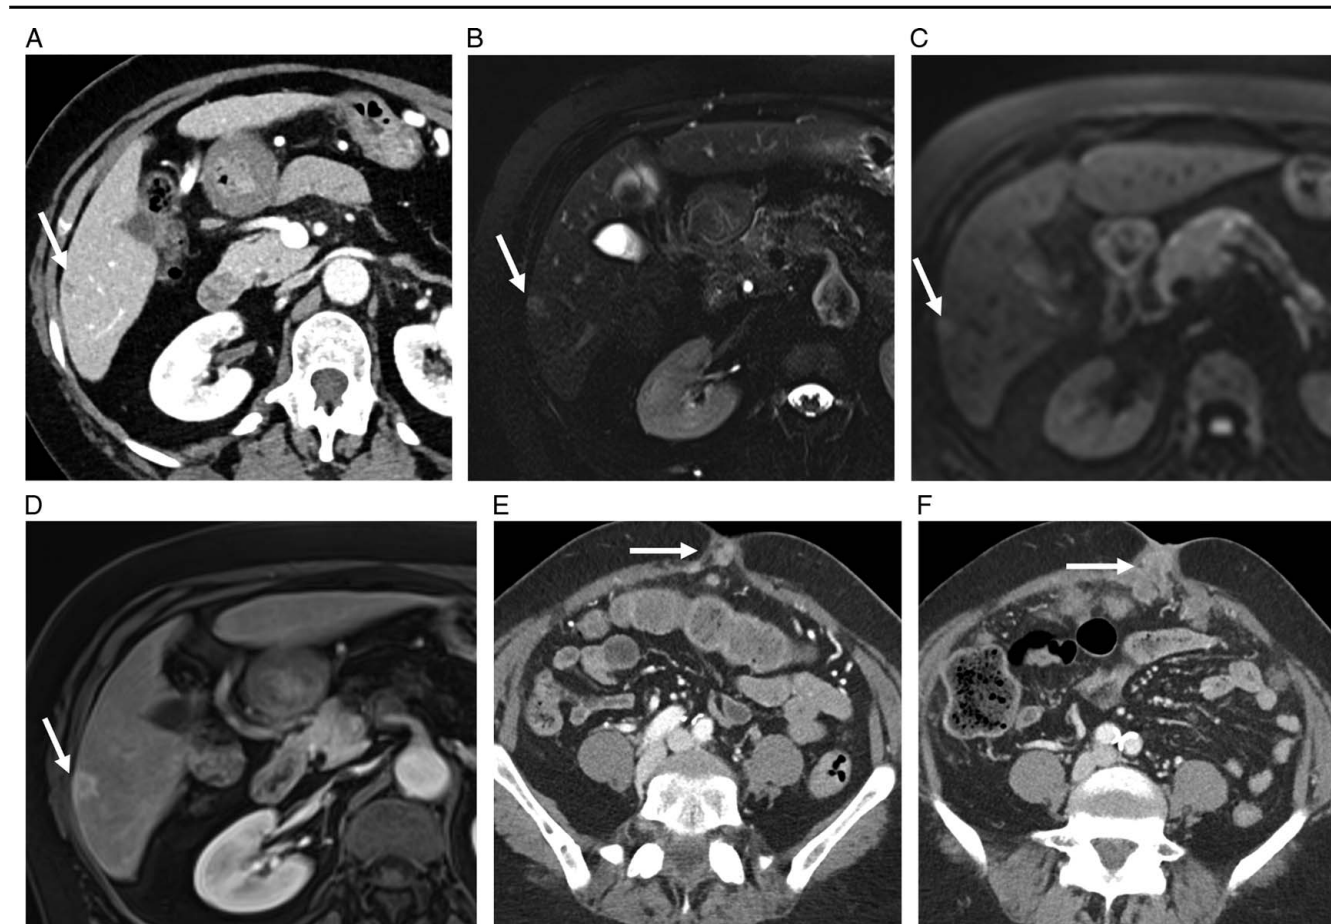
A 61-year-old woman with pancreatic ductal adenocarcinoma. (A) An axial intravenous (i.v.) contrast-enhanced computed tomography (CT) image in the portal venous phase showed a 5-mm indeterminate liver lesion (arrow). (B) An axial T2-weighted MR (magnetic resonance) image showed a subtle T2 hyperintense liver lesion (arrow). (C) An axial diffusion-weighted MR image showed mild diffuse restriction within the liver lesion (arrow). (D) An axial i.v. contrast-enhanced T1-weighted MR in the portal venous phase showed avid peripheral enhancement. MRI features were highly suspicious for liver metastases. Follow-up axial i.v. contrast-enhanced CT images in the portal venous phase obtained 5 months (E) and 7 months (F) later showed progressive enlargement of multiple enhancing peritoneal nodules (arrows), also known as Sister Mary Joseph nodules, compatible with peritoneal carcinomatosis.
